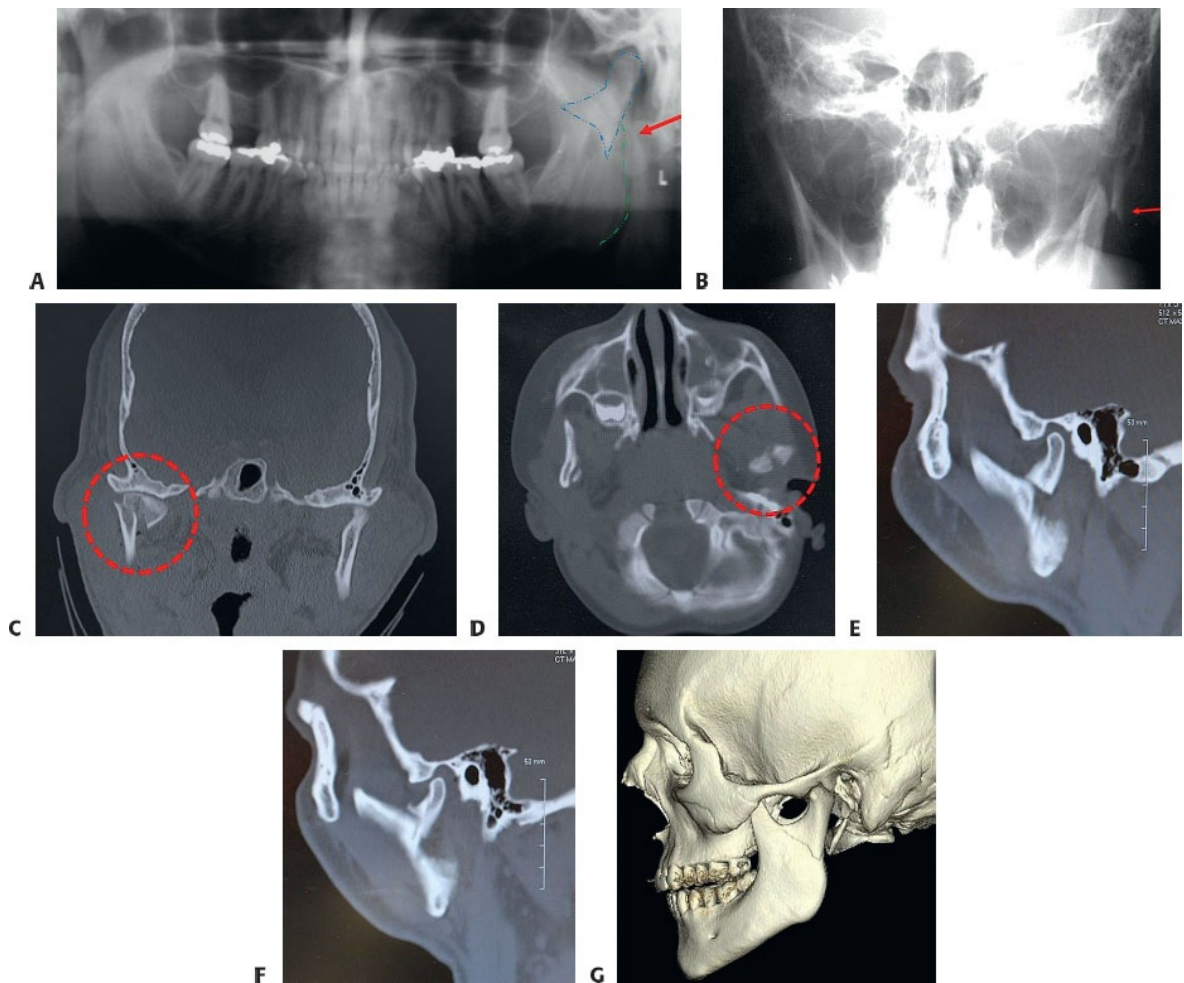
• A. Orthopantomogram of left condylar base fracture. B. Towne's view showing laterally displaced fracture. Coronal (C) and axial (D) CT scans of condylar head fractures in two different patients. (The author would not approach these surgically, although some would.) E,F. Sagittal CT sections of right and left condylar neck and base fractures. G. 3D CT scan of condylar base fracture.
